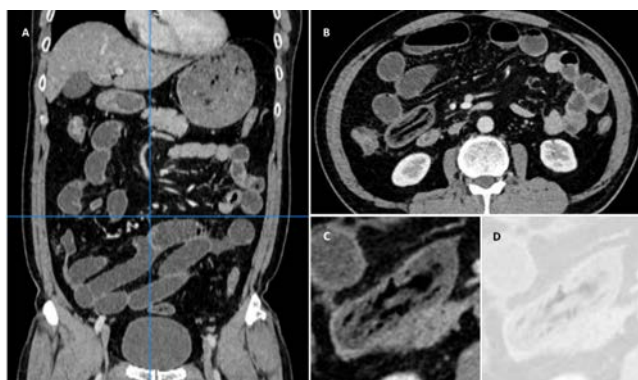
Computed tomography (CT) findings of small bowel obstruction due to shiitake mushroom bezoar. A) Coronal non-contrast CT shows dilated small bowel loops and collapsed terminal ileum, indicating a proximal obstruction; B) A transition point in the right iliac fossa with an intraluminal mottled gas pattern suggestive of a bezoar; C) The bezoar's irregular low-attenuation pattern, consistent with its composition; D) The lung window setting on CT distinguishes the bezoar from fecal material by enhancing contrast and revealing its characteristic low-attenuation pattern.
